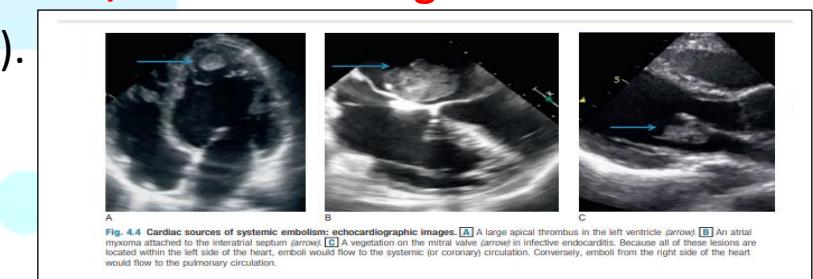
Cardiac sources of systemic embolism: echocardiographic images. A A large apical thrombus in the left ventricle (arrow). B An atrial myxoma attached to the interatrial septum (arrow). C A vegetation on the mitral valve (arrow) in infective endocarditis. Because all of these lesions are located within the left side of the heart, emboli would flow to the systemic (or coronary) circulation. Conversely, emboli from the right side of the heart
